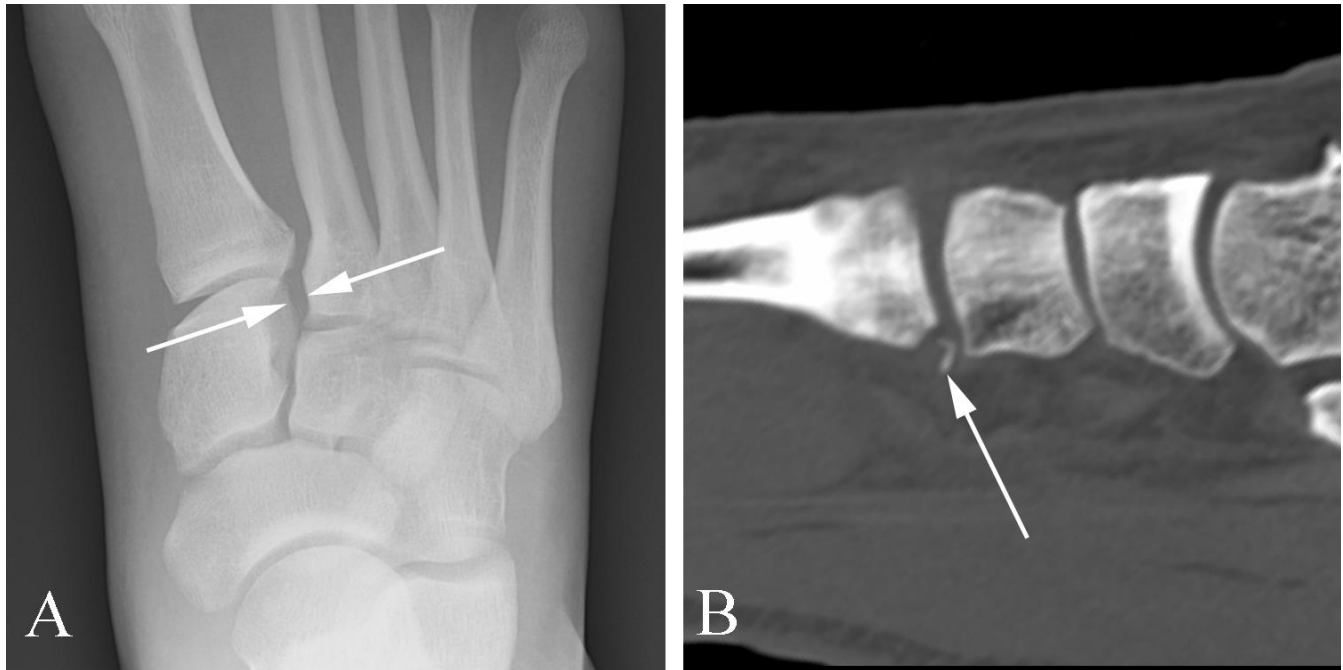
Lisfranc fracture in a 22 year old woman with acute foot pain following trauma. A. Oblique plain film examination of the foot demonstrates abnormal separation of the medial cuneiform and base of the second metatarsal (arrows). B. Sagittal reformatted CT study shows a small fracture fragment off of the second metatarsal base (arrow), compatible with avulsion of the plantar tarsal-metatarsal ligament.
